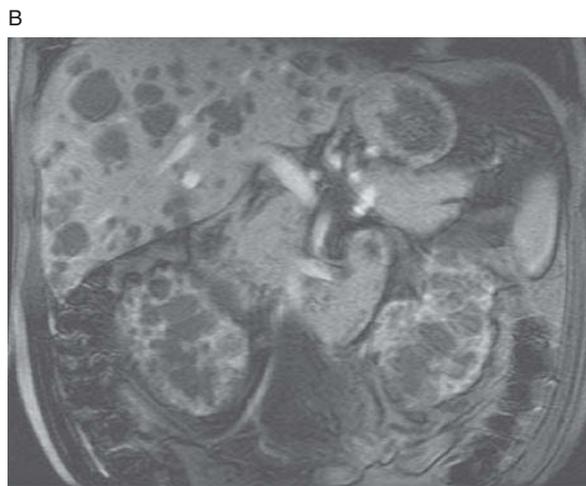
Liver cysts. Axial T2-weighted image (A) demonstrates numerous T2-bright lesions of various sizes within the liver and kidneys. Coronal, T1-weighted, fat-saturated contrast-enhanced image (B) demonstrates no evidence of enhancement. This patient has polycystic disease involving the liver and kidneys.
